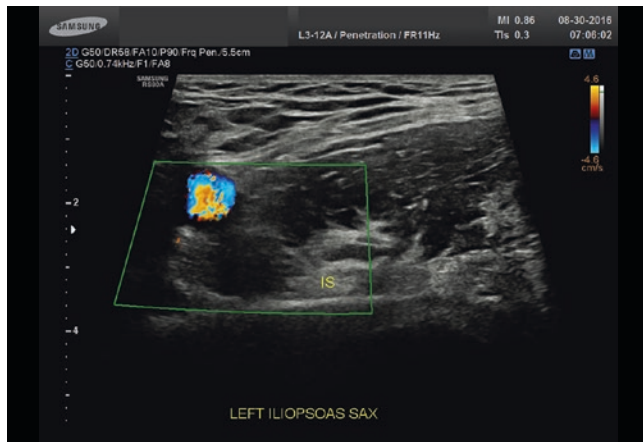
Transverse image of the iliopsoas tendon at the iliopsoas area. Doppler shows the femoral vessels, which are located just medial to the tendon. Right side of the image is lateral. IS iliopsoas tendon. (Image courtesy of Steve Wisniewski)
